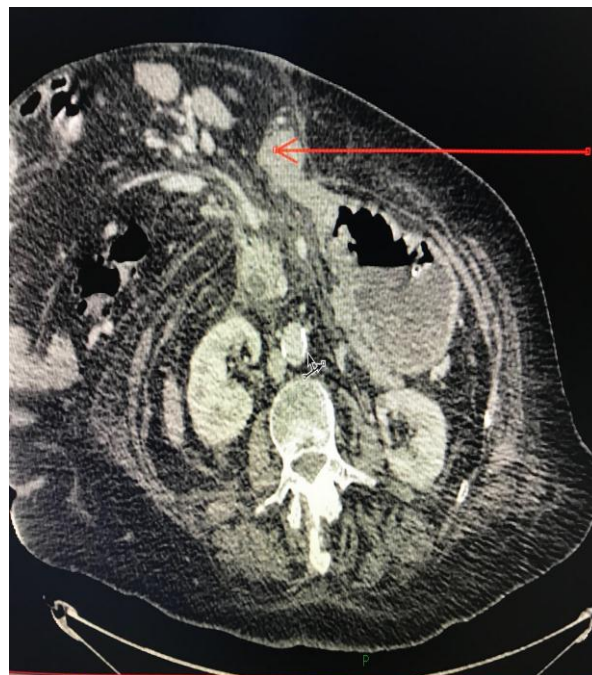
Axial CT image demonstrating a large incisional hernia with the distal stomach, duodenum (arrow) and part of the pancreas within the sac.
